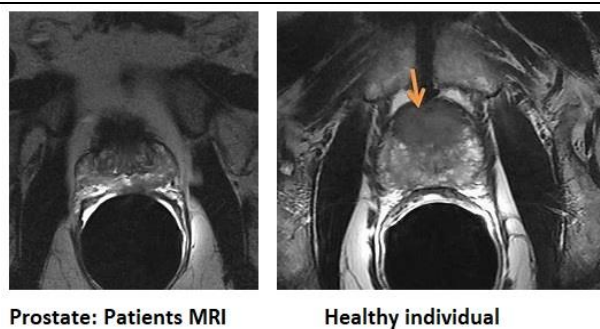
MRI of prostate cancer patients and healthy individuals
